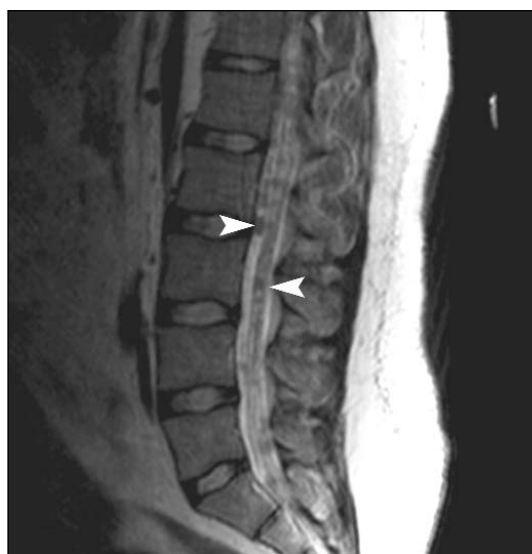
Sagittal T2-weighted MRI of the lumbar spine. There is evidence of thickening and nodules over the nerve roots of the cauda equina.
